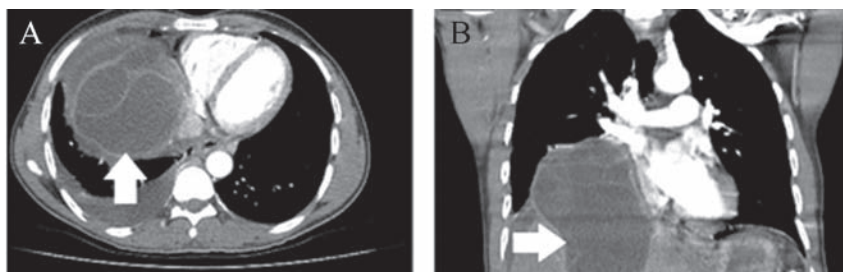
(A) Coronal and (B) sagittal section CT images of the thorax and upper abdomen. A large cystic mass (white arrows) is seen to arise within the liver and extend into the right hemithorax. CT = computerised tomography.
